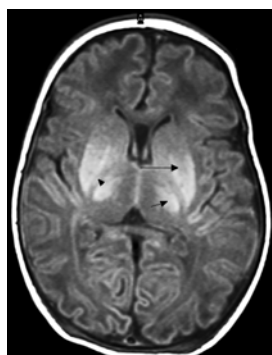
T1-weighted MR image (550/20; section thickness, 4 mm) at level of basal ganglia shows abnormally high signal intensity in basal ganglia (long arrow), thalamus (short arrow), and posterior limb of internal capsule (arrow head) in infant born at a gestational age of 37 weeks 5 days with severe perinatal asphyxia due to intertwined umbilical cord. Imaging was performed 6 days after birth at a postconceptional age of 38 weeks 4 days.
